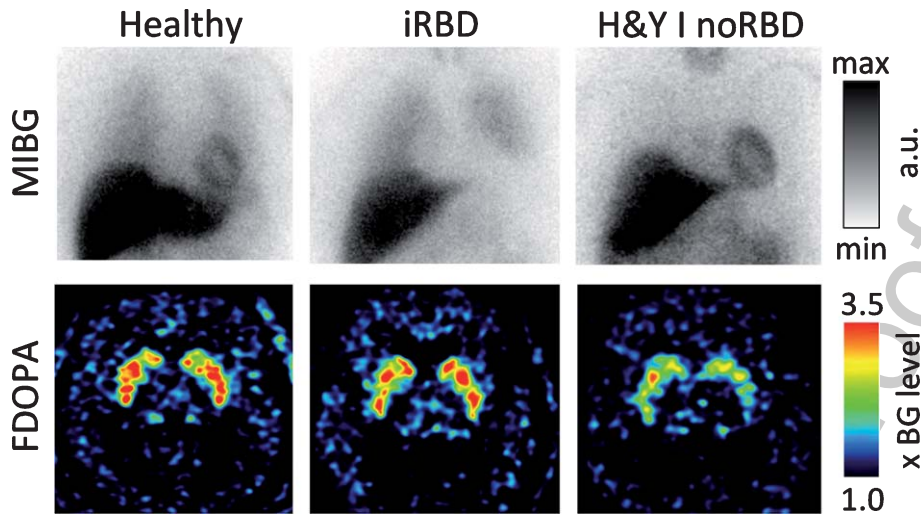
The cardiac sympathetic innervation imaged with ^{123}I -MIBG scintigraphy (top row) and the nigrostriatal dopamine storage capacity image by ^{18}F -DOPA PET (bottom row) in a healthy control (left column), a patient with idiopathic RBD (iRBD; middle), and a *de novo* H&Y stage I PD patient without RBD (right). Note that the iRBD patient shows severely reduced sympathetic cardiac innervation but almost normal striatal dopaminergic storage capacity. In contrast, the *de novo* PD patient without RBD shows normal cardiac innervation but markedly reduced striatal dopamine storage capacity. These cases represent the hypothesized PNS-first and CNS-first phenotypes, respectively. [MIBG heart/mediastinum ratios are scaled arbitrarily. The FDOPA images are scaled from 1 to 3.5 times the cortical background intensity.]
